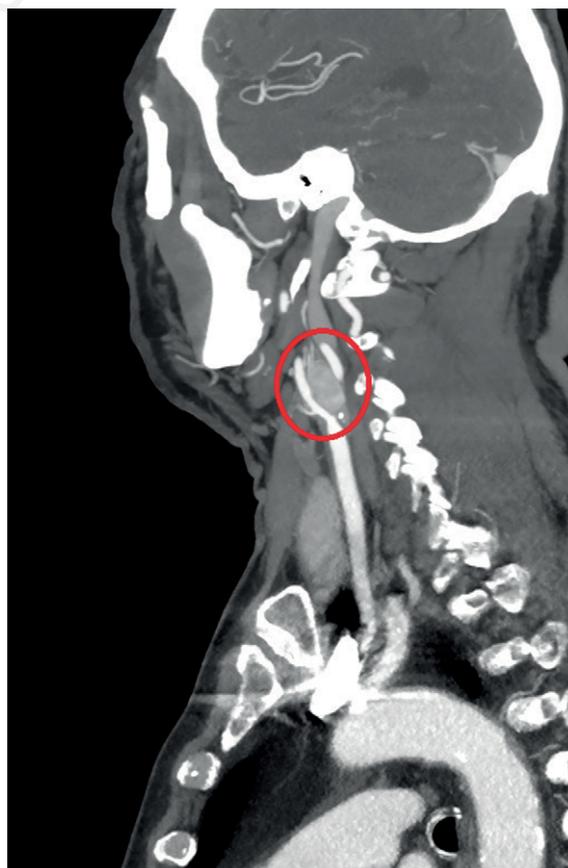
Lateral MR imaging of chemodectoma.
